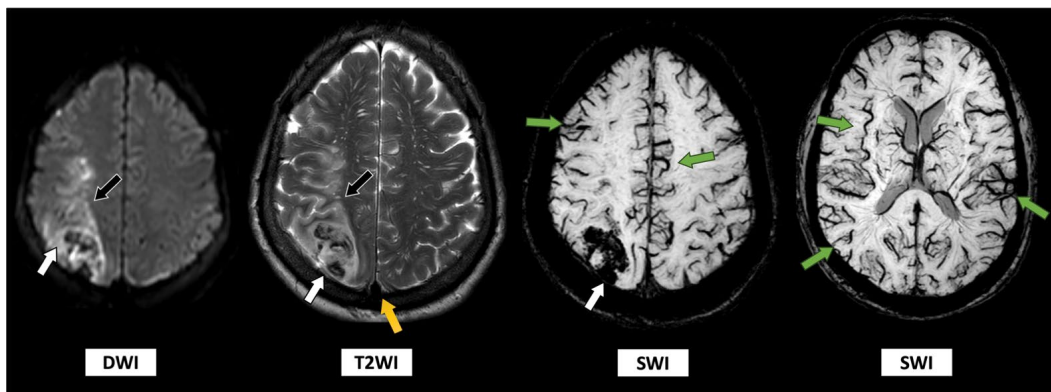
Magnetic Resonance Imaging (MRI) after worsening of the clinical findings.
